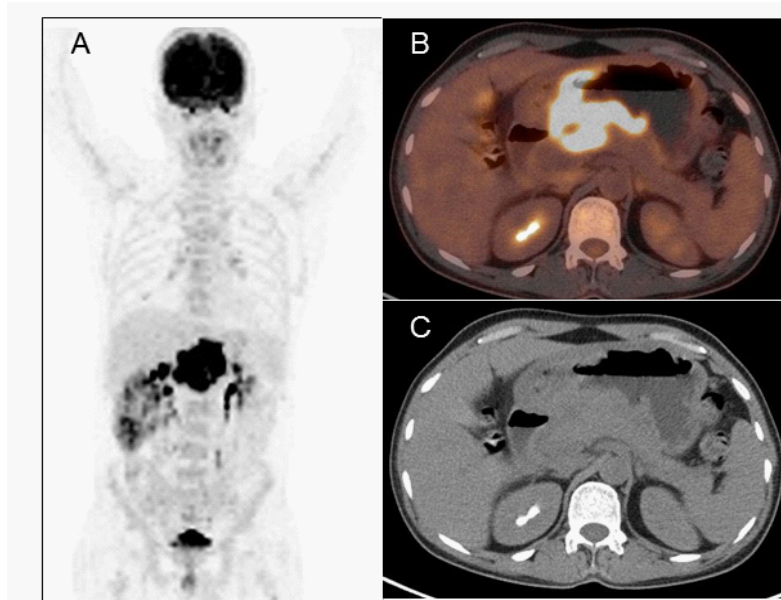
40-years old male was diagnosed with gastric DLBCL, and underwent staging 18F-FDG-PET/CT. Maximum intensity projection image showed metabolically active lesion in the middle in the abdomen (A), which corresponded to a lobulated mass in the antropyloric region of the stomach on the axial fused PET/CT (B) and CT images (C). No perigastric lymph nodes were noted. Faintly FDG avid subcentimetric mediastinal lymph nodes, and consolidation in the right lung lower lobe were also noted (A), suggestive of secondary infective etiology. The patient, thus, had stage I disease as per the Lugano staging system.
